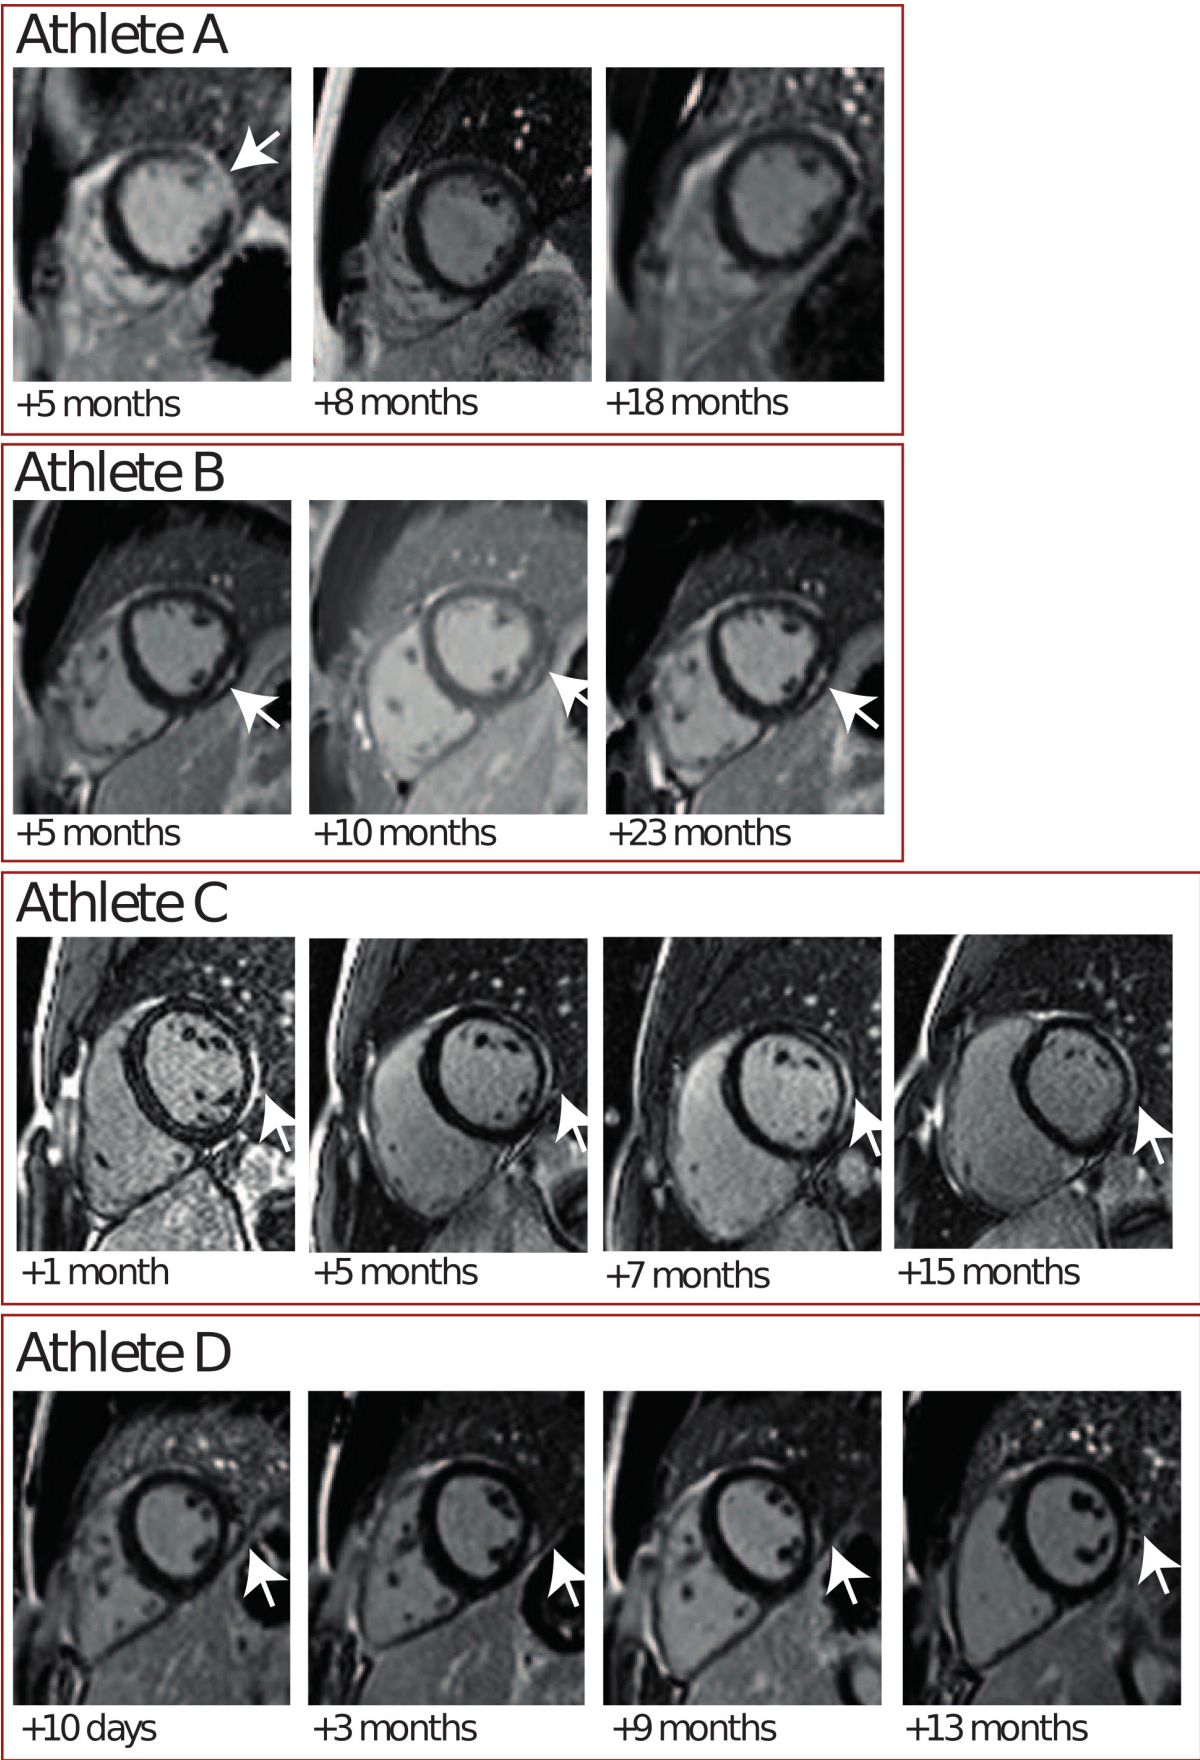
Short-axis late gadolinium enhancement (LGE) images of individual sequential CMRs performed in four athletes with SARS-CoV-2 associated pericardial/myocardial LGE demonstrated with an arrow including time interval between infection with SARS-CoV-2 and CMR. CMR, cardiovascular MRI.
